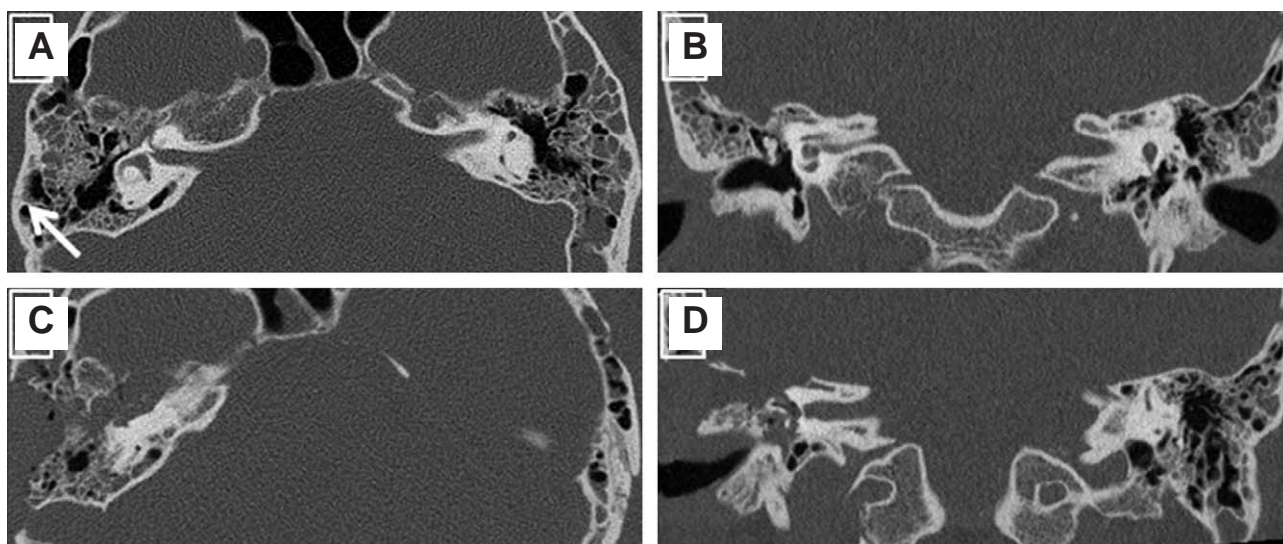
Preoperative (A, B) and postoperative (C, D) HRCT images of patient no. 1, longitudinal fracture line (white arrow) of the temporal bone in axial view of the right temporal bone (A), Traumatic fluid collection of both mastoids and right middle ear cavity (B), Middle cranial fossa approach of axial view (C) and coronal view (D)
